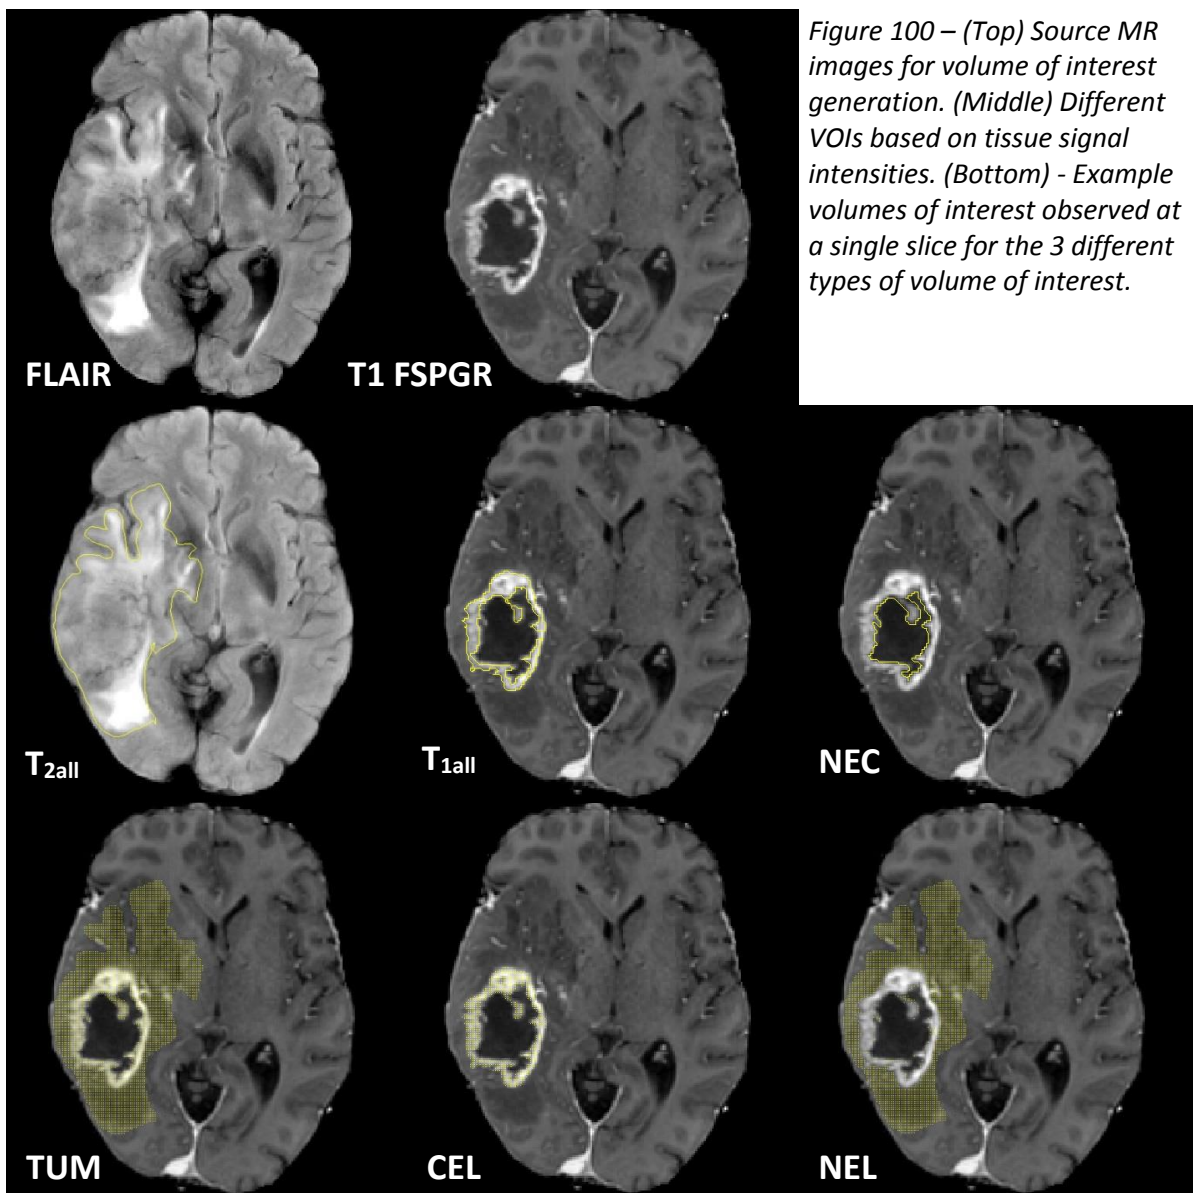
(Top) Source MR images for volume of interest generation. (Middle) Different VOIs based on tissue signal intensities. (Bottom) - Example volumes of interest observed at a single slice for the 3 different types of volume of interest.
